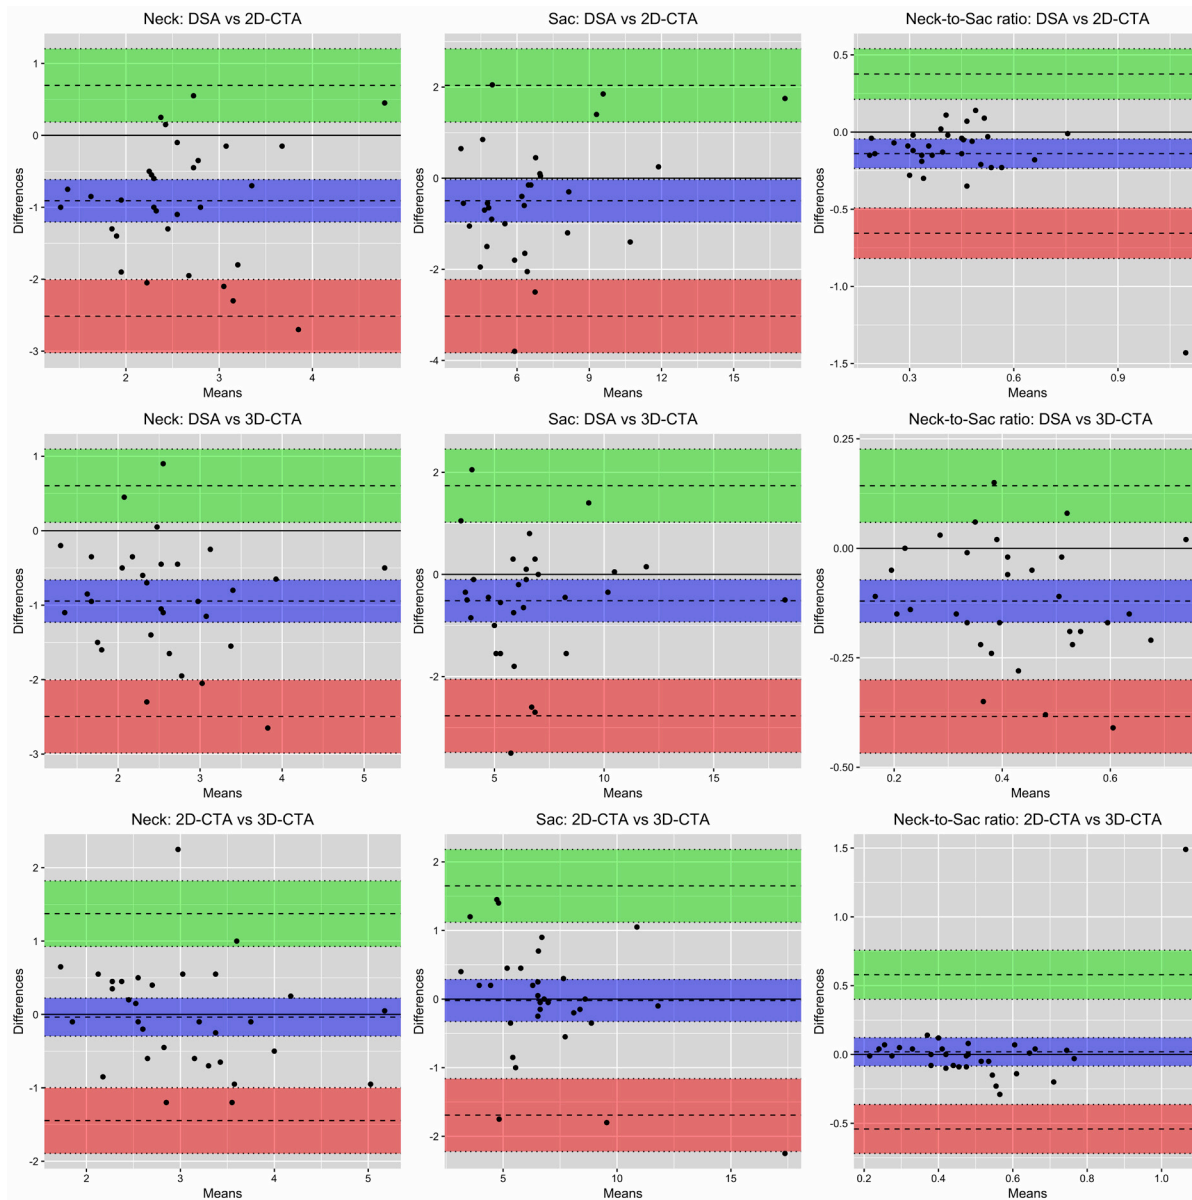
Bland-Altman plots. Computerised tomographic angiography (CTA) overestimated the aneurysmal maximal sac (by approximately 0.5 mm) and neck diameters (by approximately 1 mm) in comparison to digital subtraction angiography (DSA).
